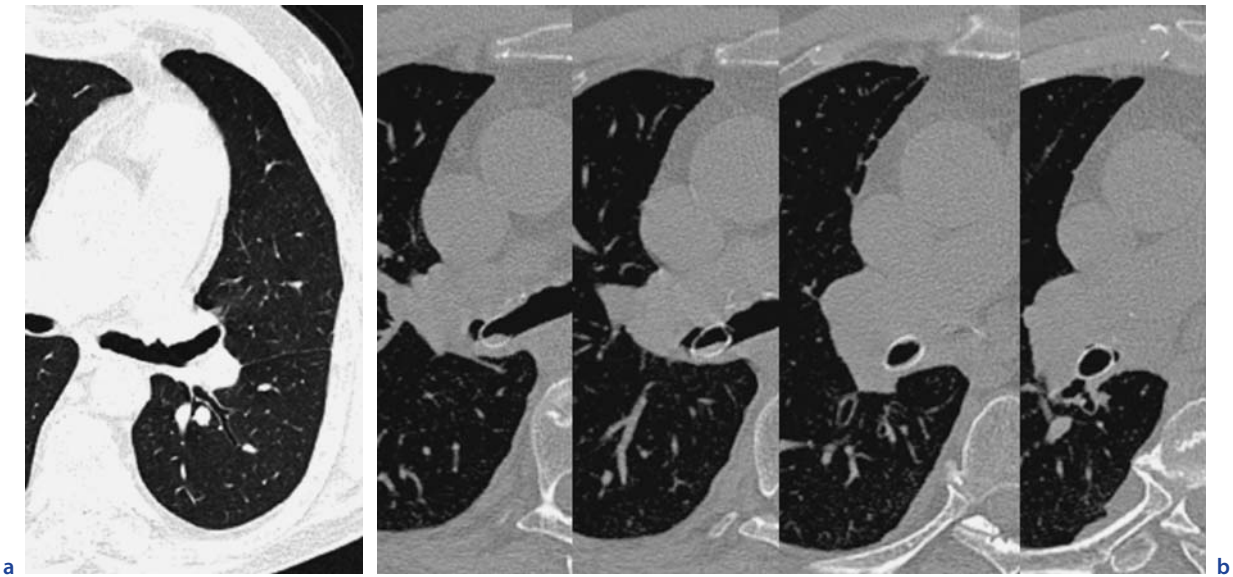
Transverse CT scan in double-lung transplant recipient shows irregularities of the bronchial anastomosis (a) and a stent bridging this irregularity (b)
